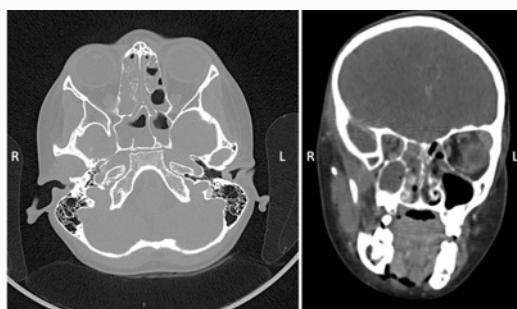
CT scan showing pansinusitis worse affecting the right sided paranasal sinuses.
